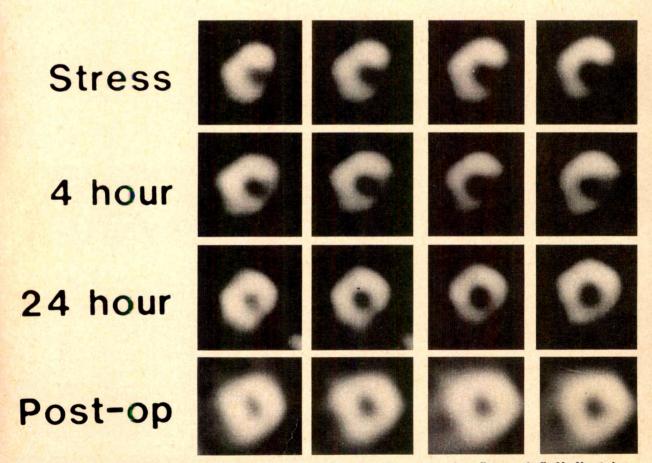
Effects of late redistribution imaging in a patient with 3-vessel coronary artery disease studied by Yang et al. 24 Short axis thallium-201 SPECT images obtained post-stress (top row) show a large lateral and inferior wall defect, which persists at 4 hr but reverses nearly completely at 24 hr. Repeat imaging post-stress after coronary artery bypass surgery (bottom row) shows normal thallium uptake. Reprinted with permission of the American College of Cardiology. 24
